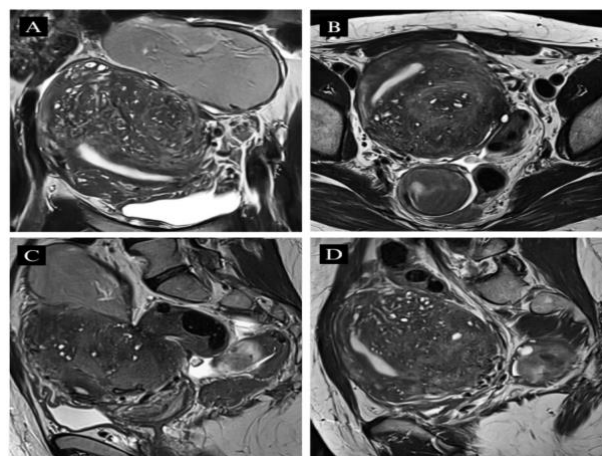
T2-weighted MRI of the Pelvis
